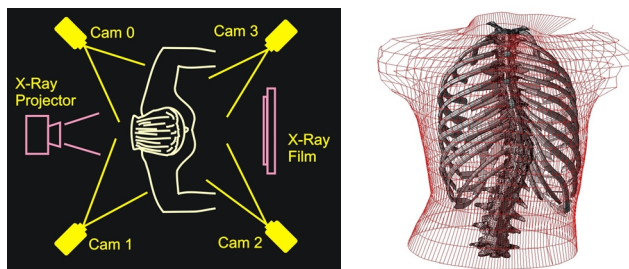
a) Laser cameras and X-ray layout for concurrent torso surface and spine imaging b) Superimposed 3D torso surface mesh and spine/rib cage
